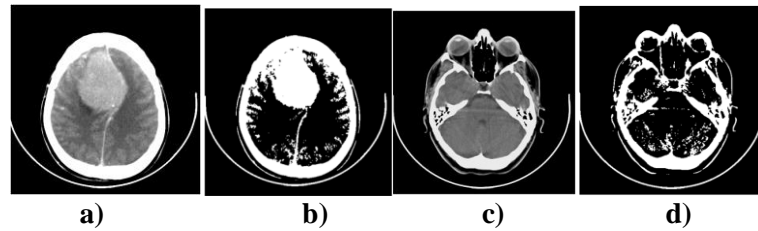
19 Otsu's algorithm applied to CT slice. a) original image, b) thresholded image, c) original image, d) thresholded image.
